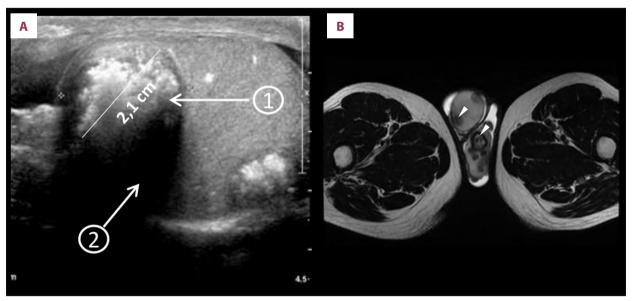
Imaging from testicular masses in a 37-year-old man with multifocal, bilateral, malignant large-cell calcifying Sertoli cell tumors (LCCSCTs). (A) Testicular ultrasound showing intratesticular hyperechoic lesions (1) with acoustic shadowing (2). (B) Pelvic MRI with bilateral, multifocal, intratesticular lesions (white arrows) and a clear hypointense T2 signal.
